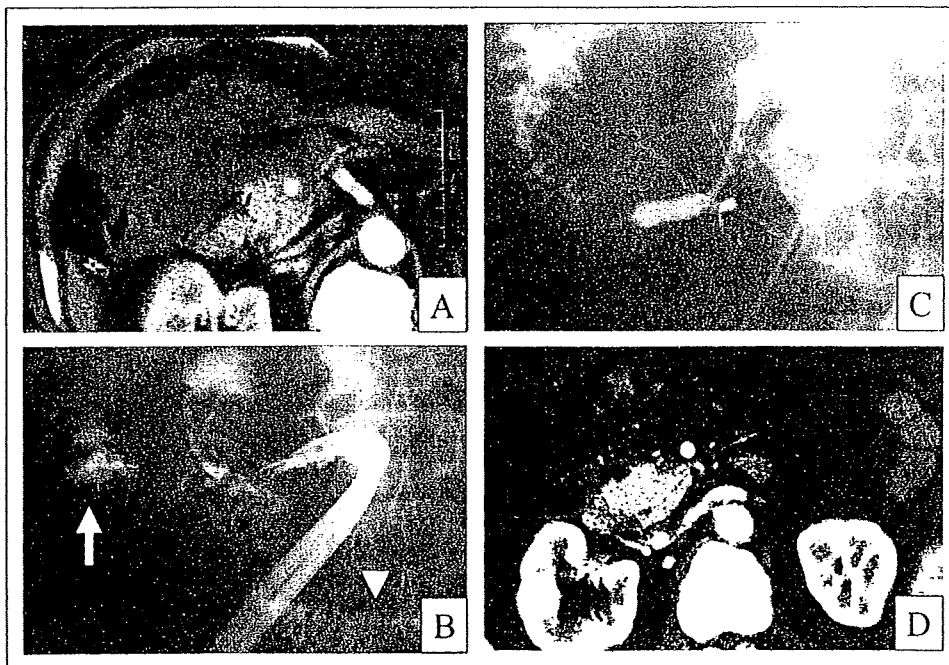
Percutaneous pancreatic duct drainage in case 1. A huge abscess was formed in the right upper quadrant (A). It was found to have penetrated into the transverse colon (arrow) and duodenum (arrowhead) (B). A drainage catheter was inserted into the main pancreatic duct (C). (D) CT scan 1 month after percutaneous pancreatic duct drainage.
